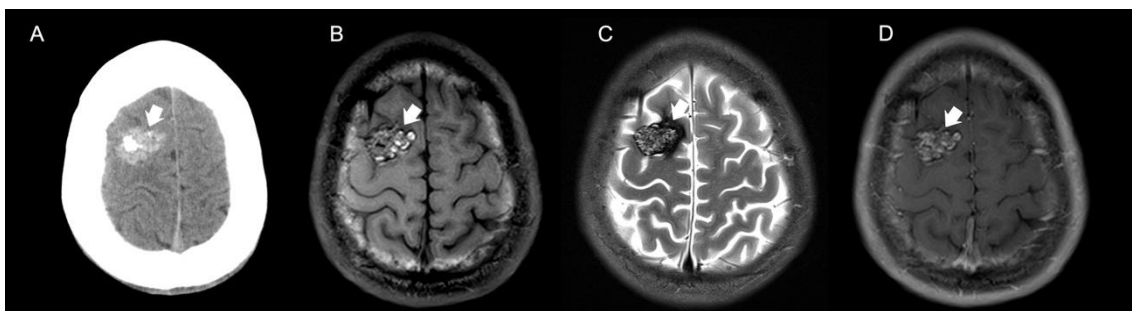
Axial unenhanced head CT scan (A) obtained in a young boy presenting with seizures reveals a well-defined, spontaneously hyperdense intra-axial lesion in the right frontal lobe with associated calcifications (*thick white arrow*), but without perilesional edema and only minor mass effect. Brain MRI including axial T1WI (B), T2WI (C) and contrast-enhanced T1WI (D) demonstrates a mixed-signal lesional core, a complete hemosiderin rim as well as absence of marked enhancement, in keeping with a cavernous malformation Zabramski type III (*thick white arrows*).
